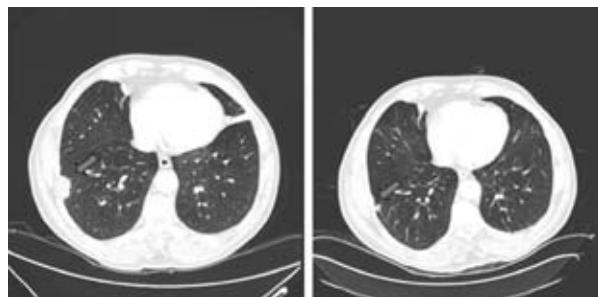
Chest CT before and after methimazole treatment
